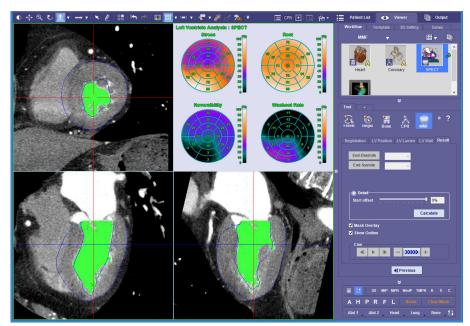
Analysis on SPECT Data
